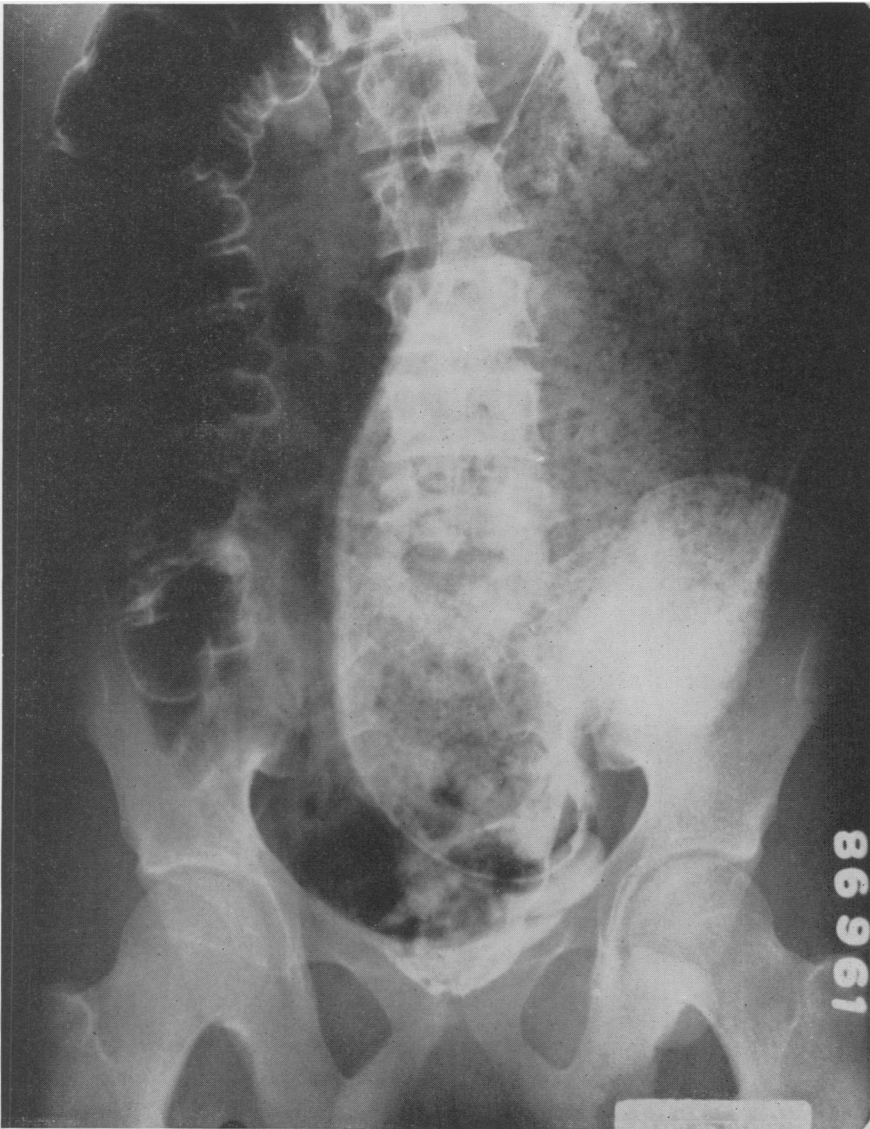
Roentgenogram of a patient who had segmental resection with an anastomosis at the level of the pelvic peritoneal reflection. Symptoms persisted following this incomplete resection. From Swenson, O.: *Pediatric Surgery*. Appleton-Century-Crofts, Inc. In Press.
